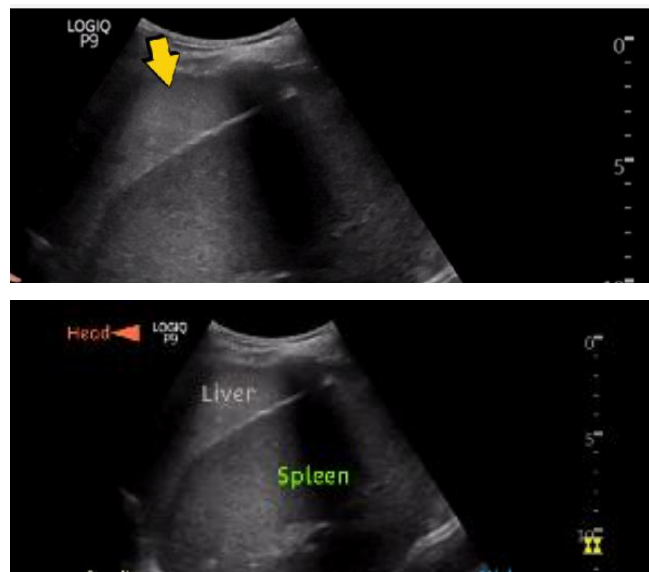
A & B - Beaver tail sign in abdominal ultrasound, the extending part of the liver (yellow arrow) can be misleading to radiologists. <https://nephropocus.com/>
